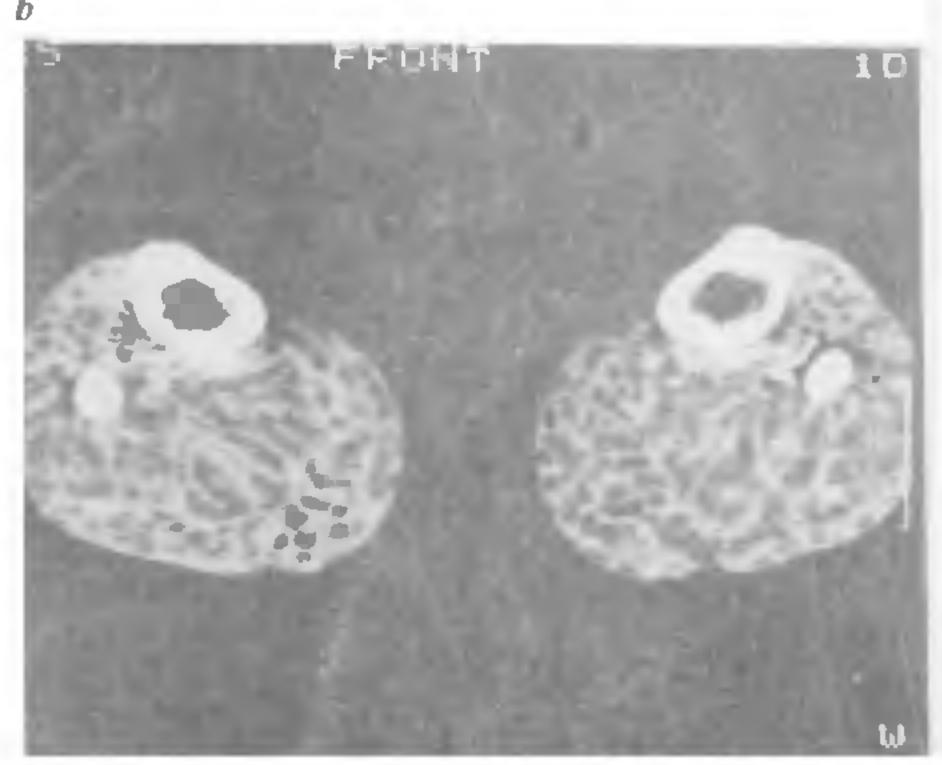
a, A pre-contrast slightly magnified axial CT scan of the brain of a young girl showing an enormous number of living cysticerci even in this one plane. The arrows point to the scolax and cyst. b, Unenhanced CT scan of call muscles in which a vast number of living cysticerci are louged. The scolices are the white dots in the more obvious cysts. They were better appreciated on enlargement.
